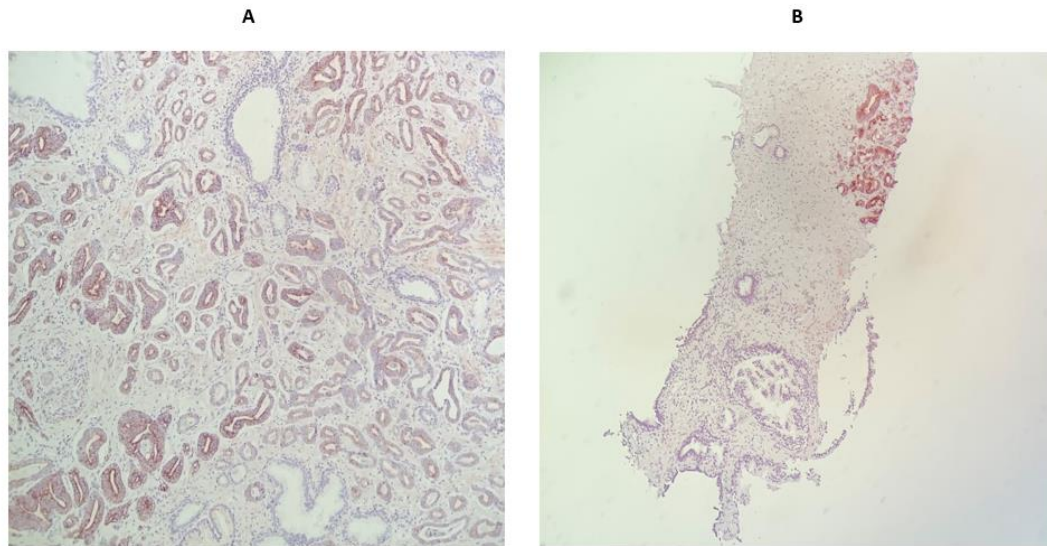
Example of PSMA IHC validation on prostate core biopsy. Note the PSMA-positive prostate adenocarcinoma, while the epithelial cells in the tiny fragment of rectal mucosa (adjacent to prostate core biopsy) are negative for PSMA. (A: 100x, B: 400x)
